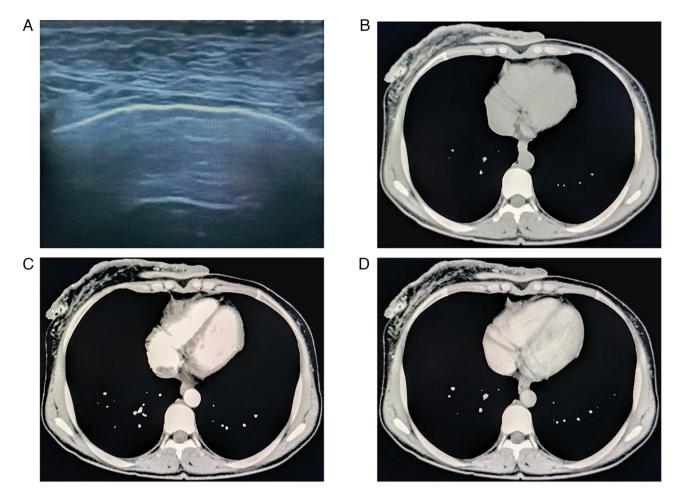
Typical ultrasonic image and CT scans. (A) Ultrasonic image. (B) CT contrast. (C) CT artery phase. (D) CT venous phase.
